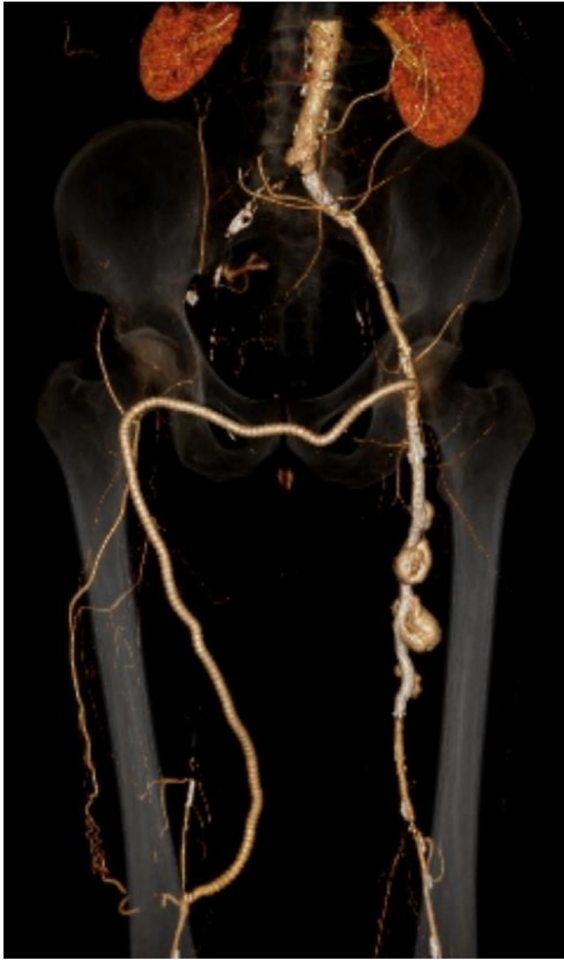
Computed Tomography Angiography reconstruction of the left femoral to right popliteal bypass, left iliac artery stent, and left superficial femoral artery pseudoaneurysms
